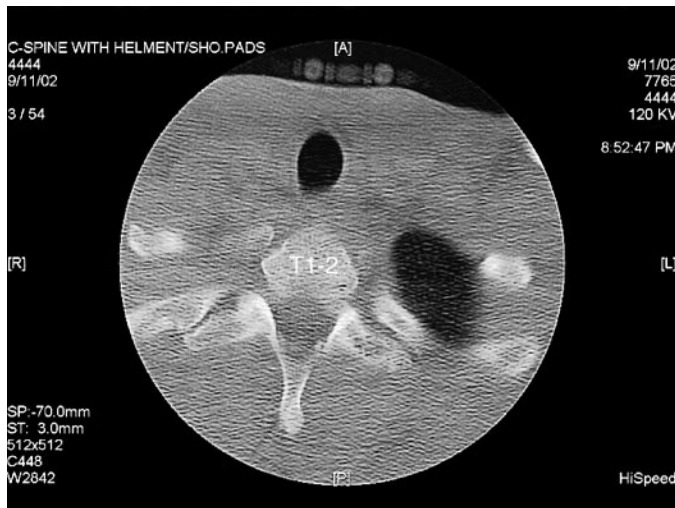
Axial computed tomography (CT) image, bone window, at T1–T2 level (same as Figure 5). Mild image degradation is due to the patient's large shoulders. Higher cervical levels are less affected. Films are fully diagnostic.
